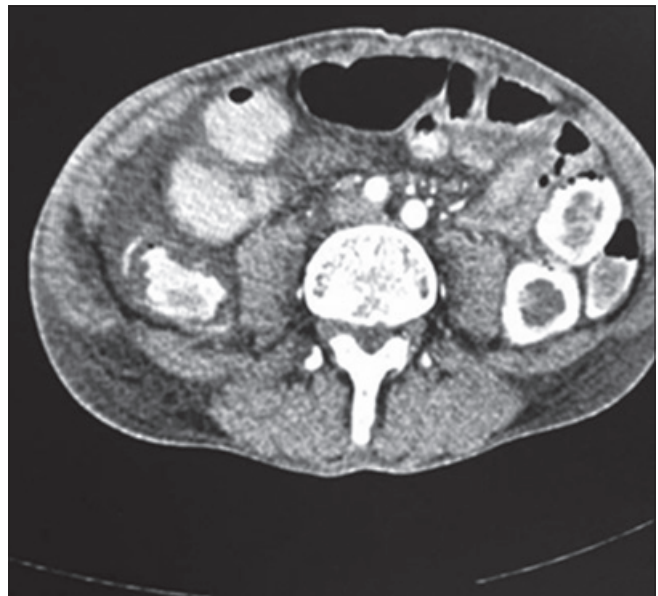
Axial postcontrast CT on Delayed sequences showing progressive filling of the intestines by extravasated contrast
